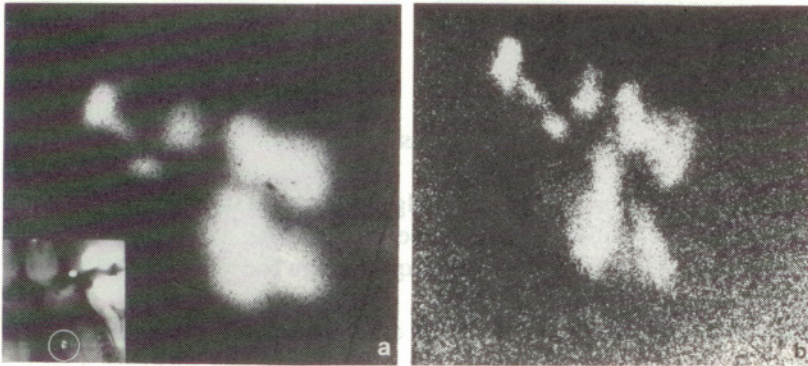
Case 1: Ante- (a) and postmortem (b) radiographs showing the morphology of the radiopaque material which has maintained its spatial configuration (magnification x 45). Inset: radiograph showing original size of amalgam fragments (circled).
